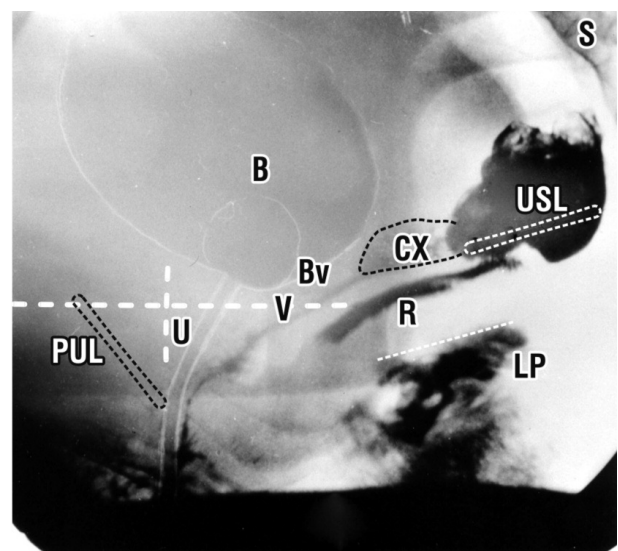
Sitting lateral x-ray (resting, closed). Even at rest, slow twitch fibres of the posterior vectors (arrows, in figure 7), gently stretch the proximal urethra backwards/downwards. U = urethra; V = vagina; B = bladder; Bv = fascial attachment of bladder base to vagina; CX = cervix; LP = levator plate.
